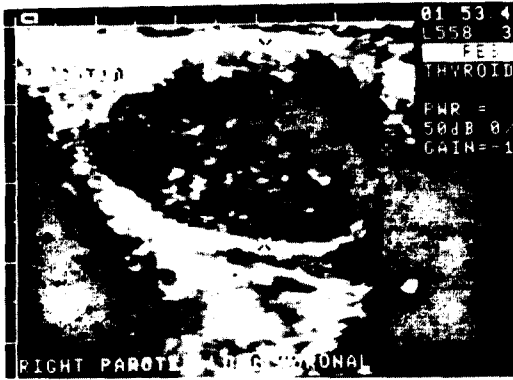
Preoperative diagnostic ultrasonogram. It shows the 3.5×2.5cm size mass(Case 1).
